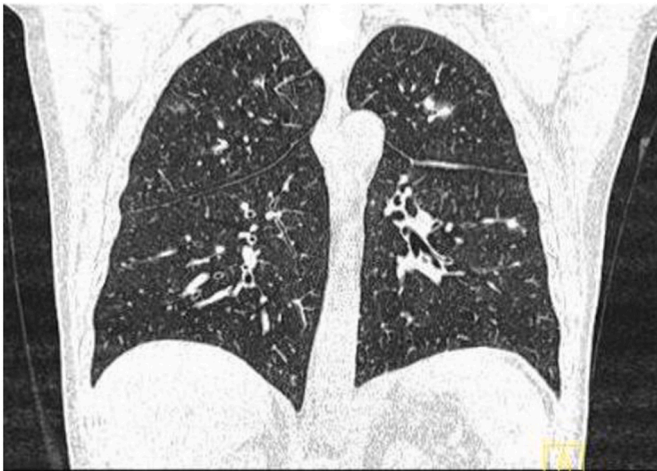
Lung CT scan performed on D+5 after second allogeneic HSCT.
